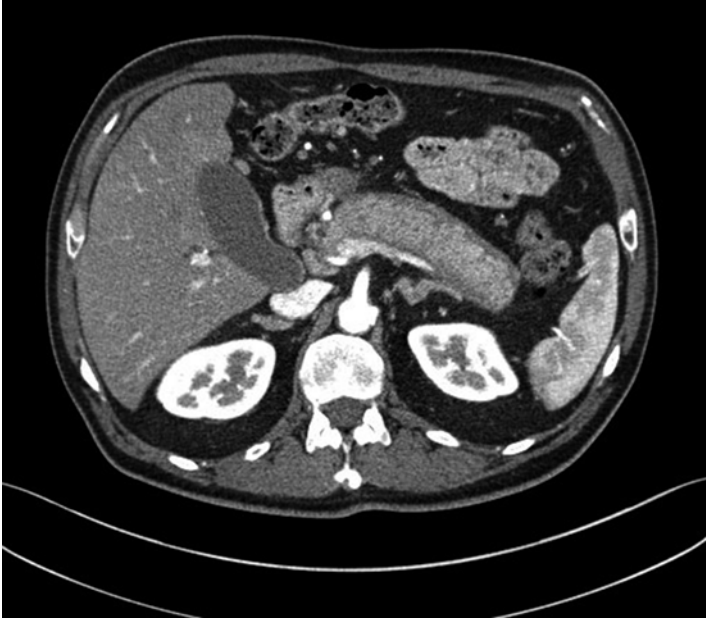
Typical features of AIP type 1 at CT scan: diffuse enlargement of the pancreas with a peripheral capsule-like rim and dilation of the intra-hepatic bile duct
